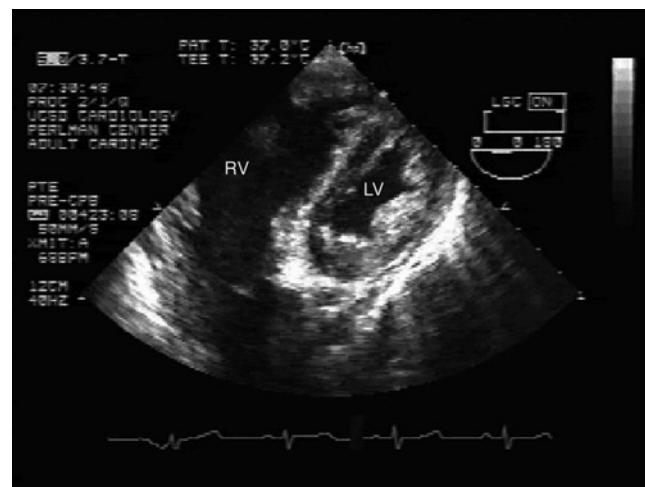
Transgastric short-axis transesophageal echocardiograph in a PTE patient with massively enlarged right ventricle. *RV* right ventricle; *LV* left ventricle.
